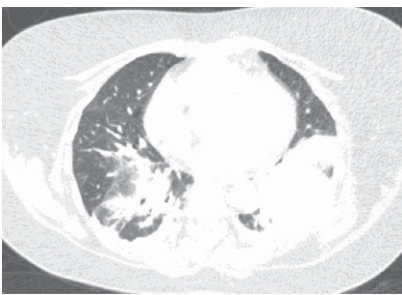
CT chest showing bibasal atelectasis, more prominent on the left.
